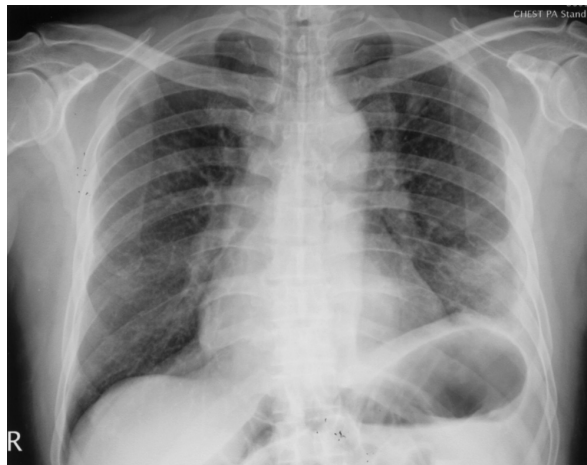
A chest radiograph showing consolidation in the left lower lung field
